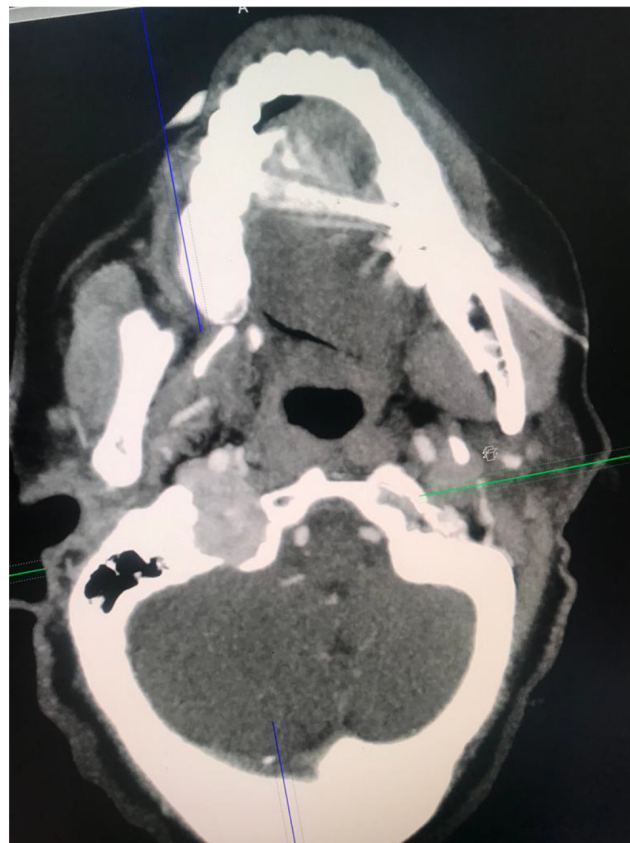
A Computed Tomography (CT) scan of the head.
